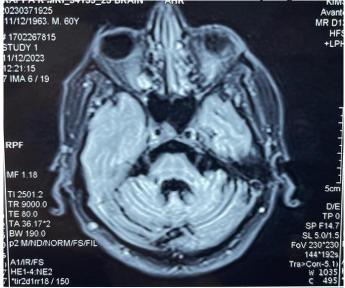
T1 MRI with hot cross bun sign of pons
